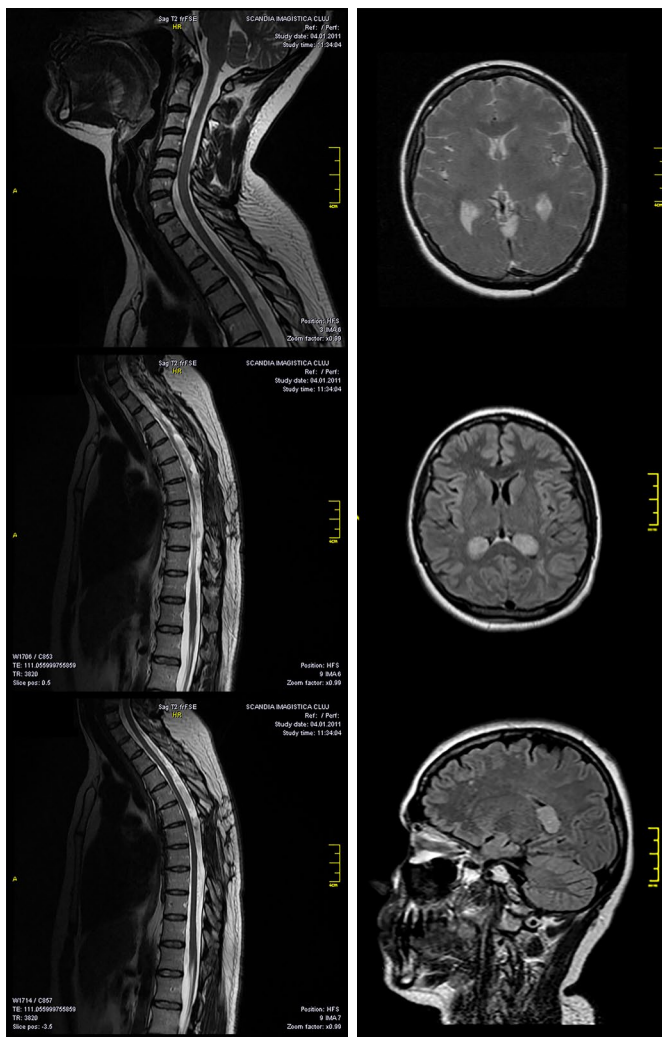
Spine MRI – T2 sequence – Sagittal view
